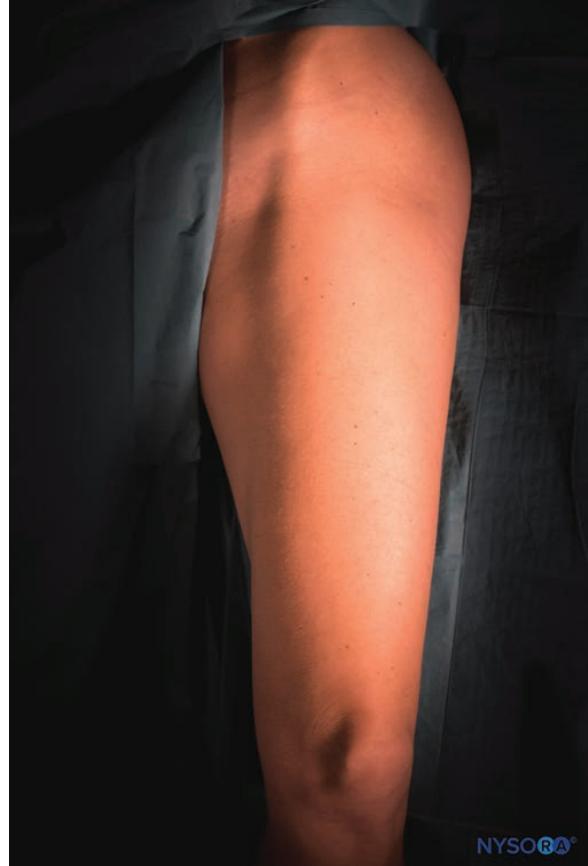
Patient position to perform an ultrasound-guided lateral femoral cutaneous nerve block.
